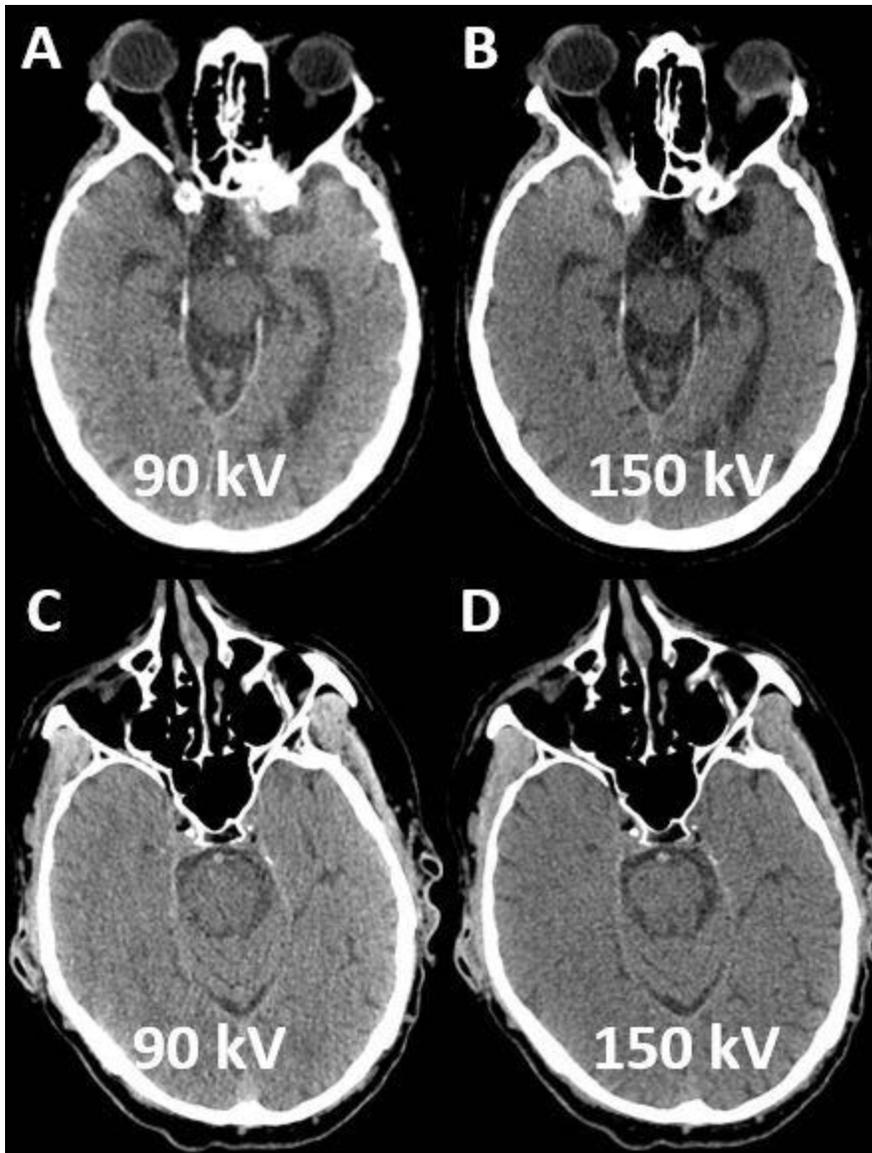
A & B: Relatively lower attenuation of basilar artery (BA) lumen on high kV on dual energy NCCT. CTA (not shown) was negative for BA clot. C & D: Relatively higher attenuation of basilar artery lumen on high kV on dual energy NCCT. CTA (not shown) was positive for BA clot.
